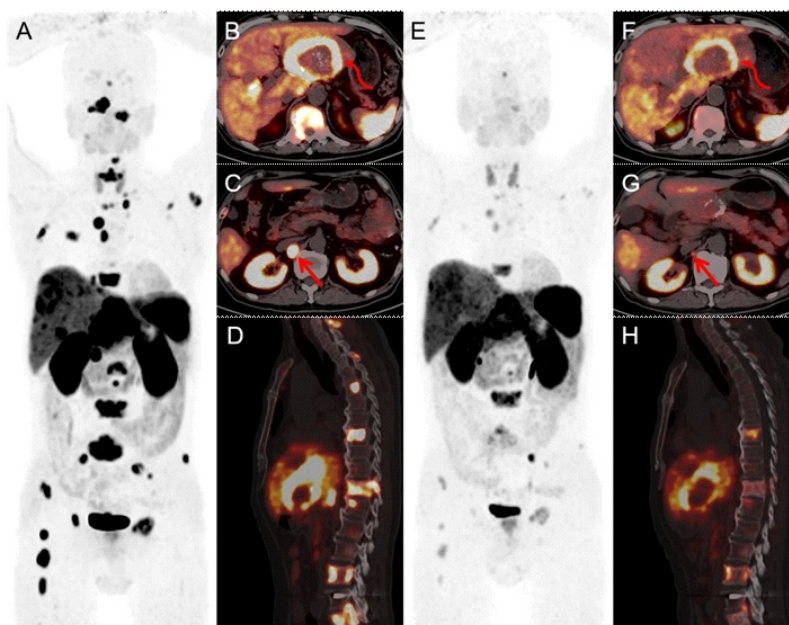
The MIP of ⁶⁸Ga-DOTATATE PET/CT before treatment showed multiple elevated tracer uptake in the whole body (A). The axial fusion images (B-D) showed multiple metastatic lesions with tracer uptake (liver metastases SUVmax 23.8, curved arrow; abdominal lymph nodes SUVmax 22.1, straight arrow; spine SUVmax 38.3). Two months after the last treatment, the MIP showed multiple shallow tracer uptake in the whole body (E). And axial (F-H) showed those metastatic lesions with significantly reduced tracer uptake (liver metastases SUVmax 15.0, curved arrow; abdominal lymph nodes SUVmax 7.0, straight arrow; spine SUVmax 16.5)
